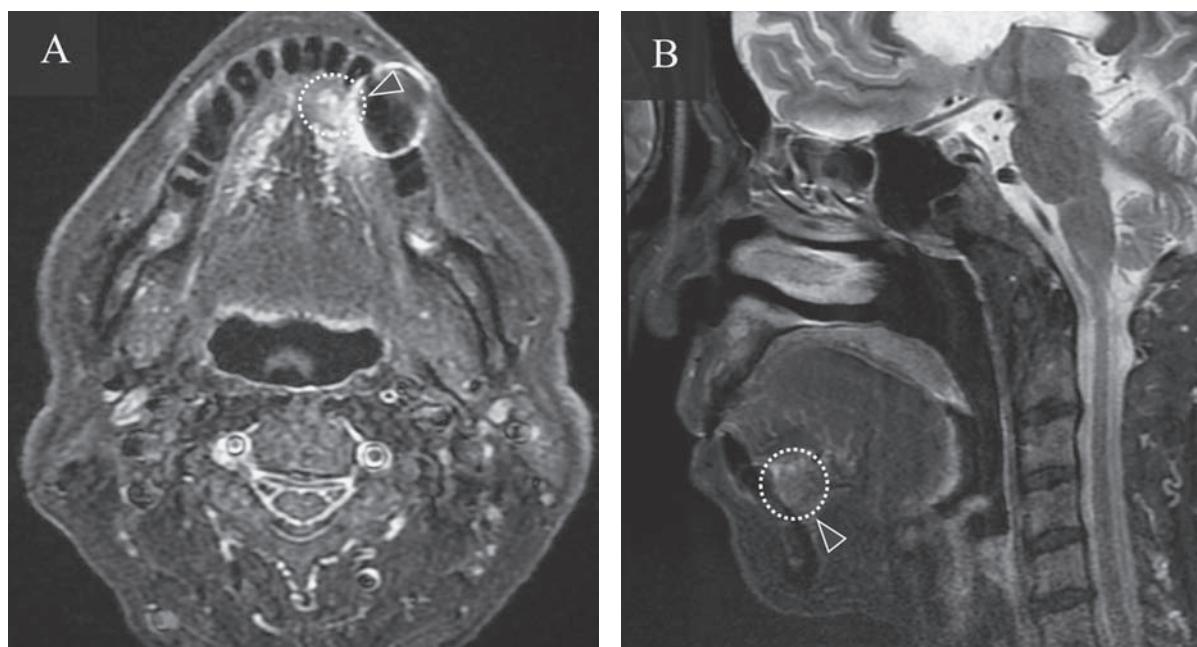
Magnetic resonance image (short TI inversion recovery) showing a contrast-enhanced lesion.
